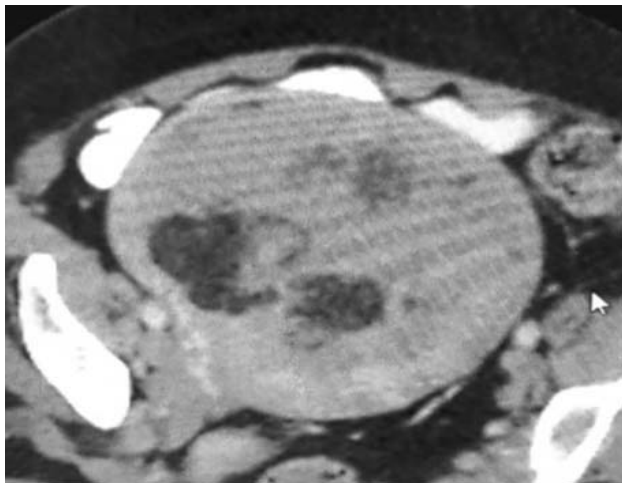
Images of pelvic CT scan axial and sagittal views demonstrating a well defined mixed density lesion arising from the anterior wall of uterus with fatty component.
